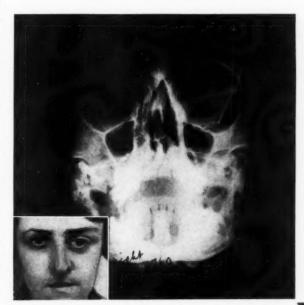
(Pfeiffer). Case 11. Hemangioma of orbit (inset). Roentgenogram showing striking enlargement of the left orbit due to increased intraorbital pressure.
